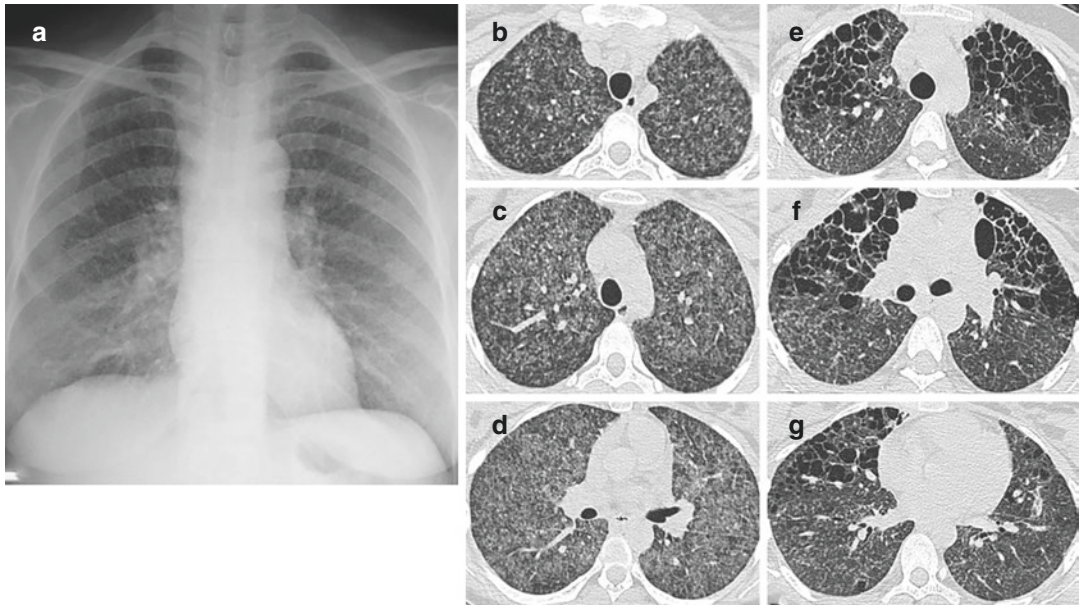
Langerhans cell histiocytosis. (a) PA chest radiograph shows a miliary pattern. (b–d) Axial CT images show diffuse ground-glass micronodules. (e–g) Follow-up CT images show appearance of confluent cysts.
